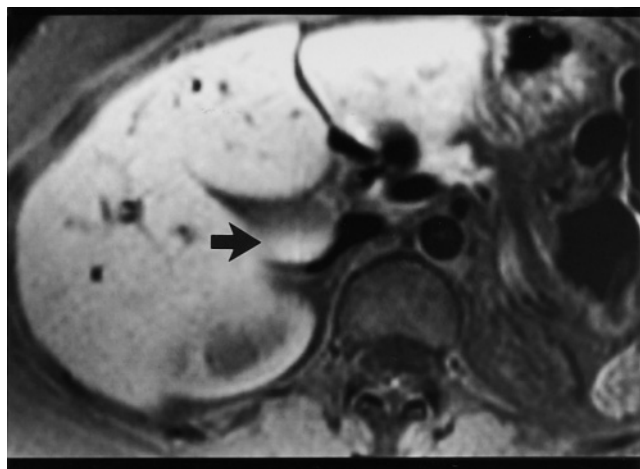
Layering of gallbladder bile. T1-weighted fat-suppressed spin-echo image. Layering of the bile in the gallbladder is observed with the more concentrated, hyperintense bile (arrow) in the dependent portion of the gallbladder.
